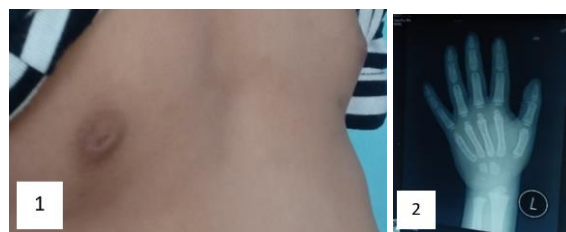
(1) Patient's breasts (Stage 3 breast development). (2) X-Ray of patient's left palm
